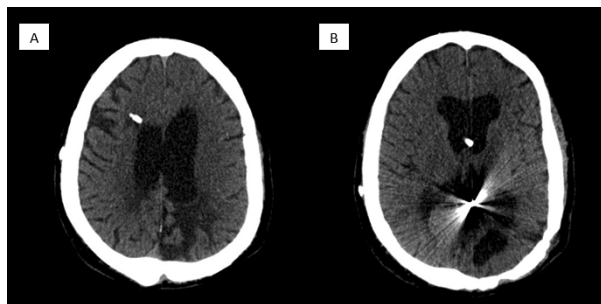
Patient no. 2 - CT scan showing A) encephalomalacia in the left occipito-parietal cortex after arterio-venous malformation (AVM) haemorrhage and B) surgical material near the corpus callosum splenium, left after AVM resection.
